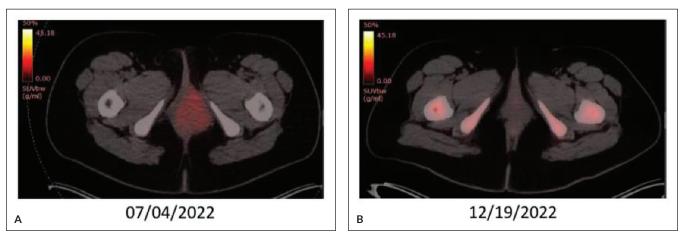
PET-CT result comparison of the pelvic area. (A) July 2022, (B) December 2022.
